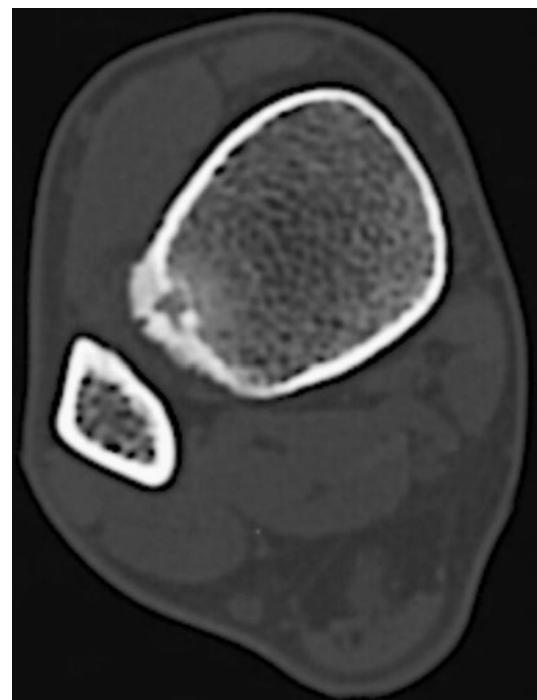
A 22-year-old man with osteoid osteoma at the right tibia (Patient 11). Computed tomography showed a low-density area 3 mm in diameter at the lateral cortex of the tibia surrounded by sclerotic change
